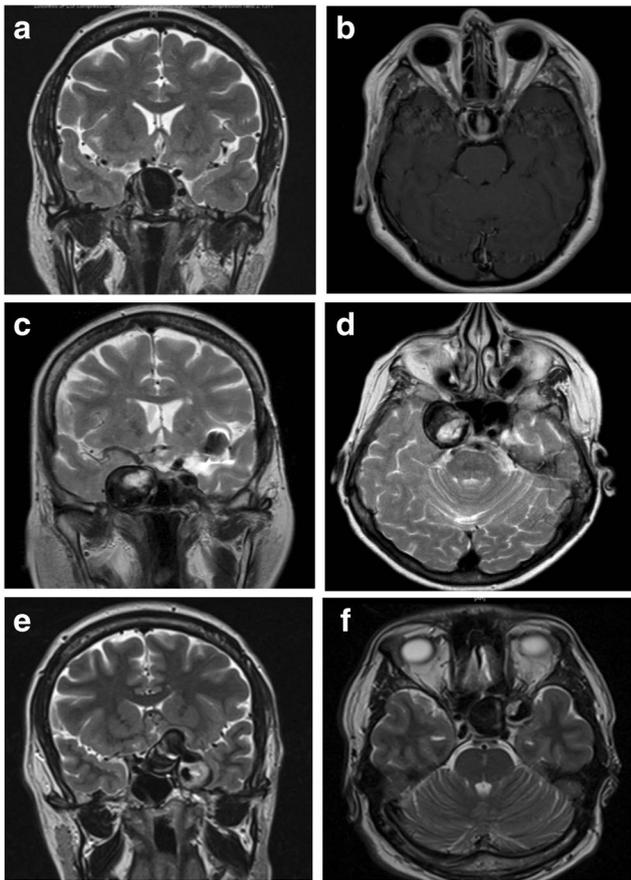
Representative MRI in three cases of each type of intracavernous mass effect. The location of mass effect was categorized in relation to the cavernous carotid artery, as medial type (a, b), lateral type (c, d) or mixed medial/lateral type (e, f), as previously described by Tang et al.
